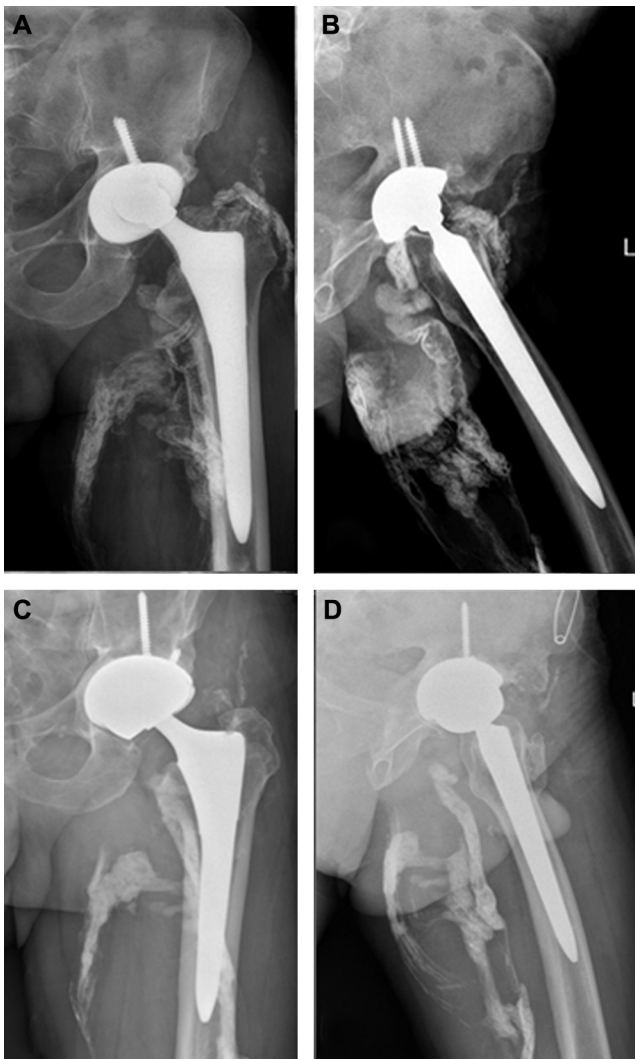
A 64-year-old male who underwent left hip arthroplasty at his third year's follow-up. Anterior posterior (A) and lateral (B) radiographies showed metallosis radiating distally through posterior compartment and eccentric position of the head. The radiographies at 4 years' follow-up after MOM revision: anterior posterior (C) and lateral (D) view.
